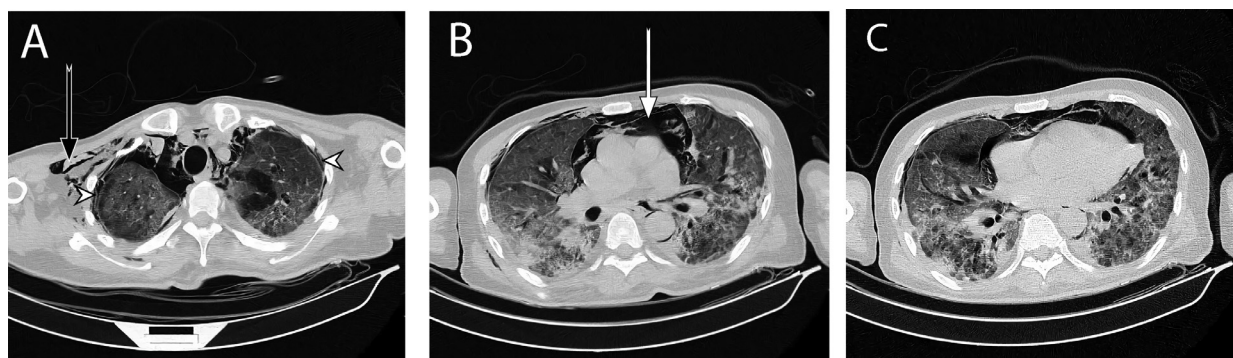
Axial noncontrast chest CT scan images of the patient acquired on the first day of admission (December 11, 2020) show bilateral ground-glass opacities and consolidation, (A) bilateral pneumothorax (white arrowheads), subcutaneous emphysema (black arrow), (B) extensive pneumomediastinum (white arrow), and (C) a small rim of pneumopericardium.
